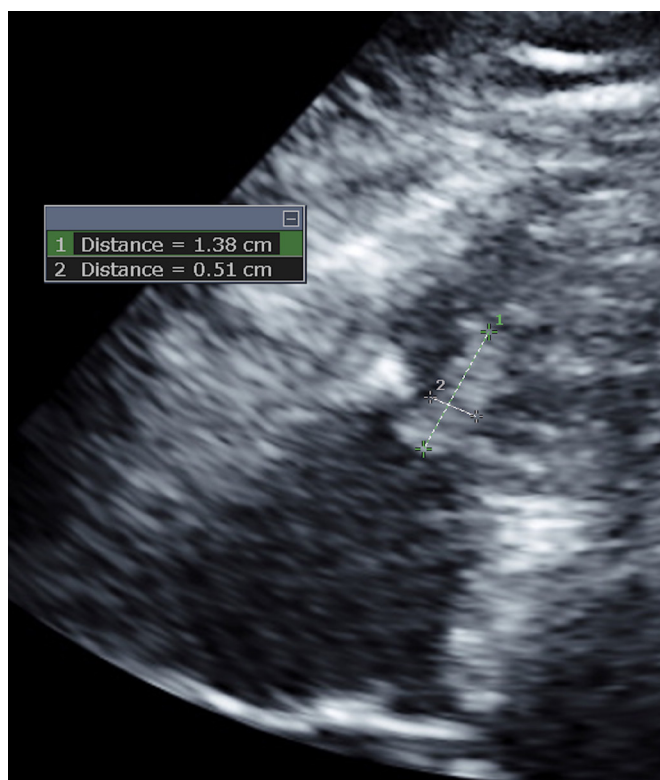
Thirty-three hours post-tissue plasminogen activator: formal trans-thoracic echocardiogram showing a mobile echodensity (14×5 mm) in the right ventricular apex near the moderator band, most likely thrombus.
